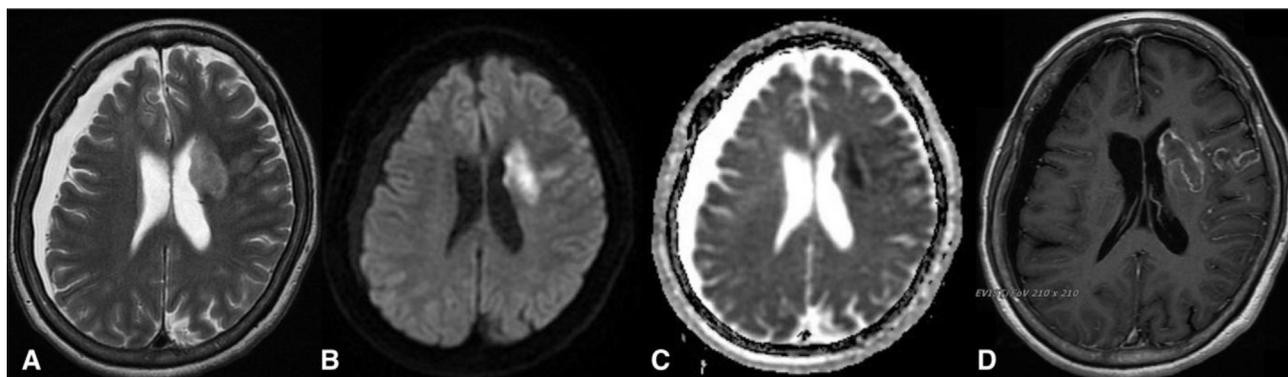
Brain MRI. Right F-T-P subdural effusion has similar signal intensity as CSF in lateral ventricles on T2-weighted imaging (A), is dark on diffusion-weighted imaging (DWI) (B), bright on apparent diffusion coefficient (ADC) (C) and no surrounding ring enhancement on contrast-enhanced T1WI (D). Subacute infarction of left basal ganglion can also be appreciated, as seen bright on DWI and dark on ADC.
